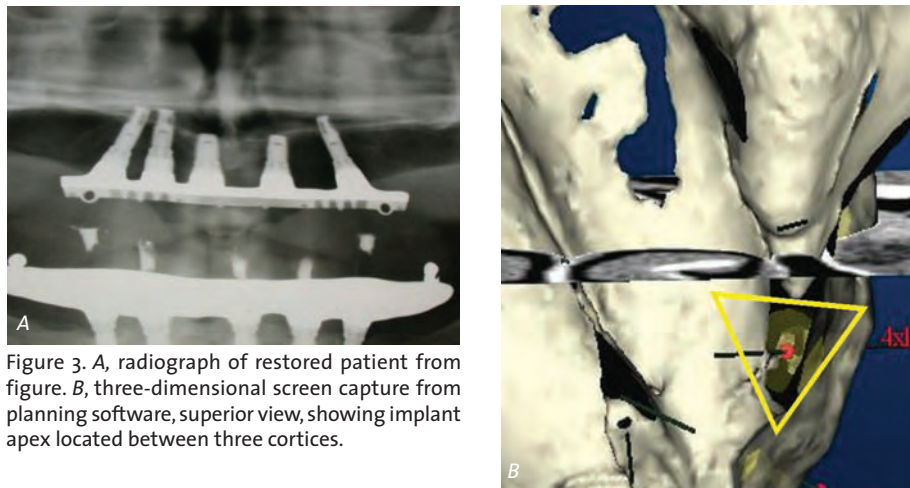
A, radiograph of restored patient from figure. B, three-dimensional screen capture from planning software, superior view, showing implant apex located between three cortices.
